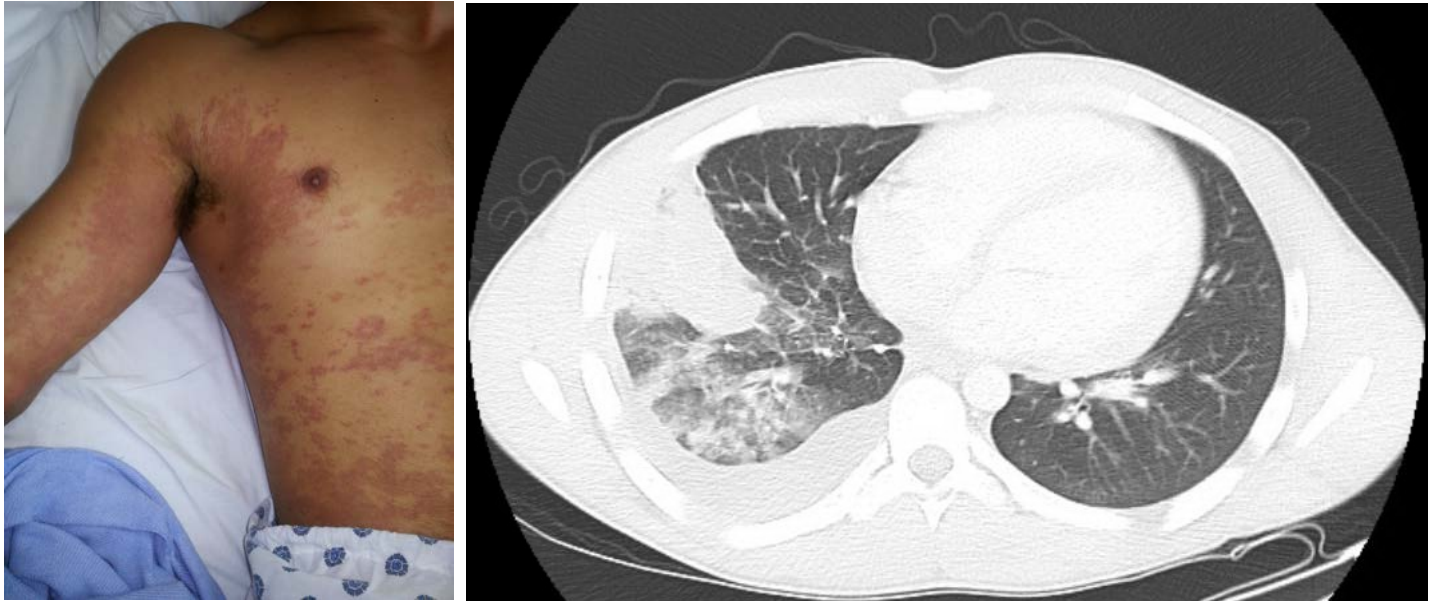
Erythematous plaques of superficial exfoliation noted in flexural areas of the upper extremities and flank. Figure 2. CT scan demonstrating right middle and lower lobe infiltrates and consolidation
